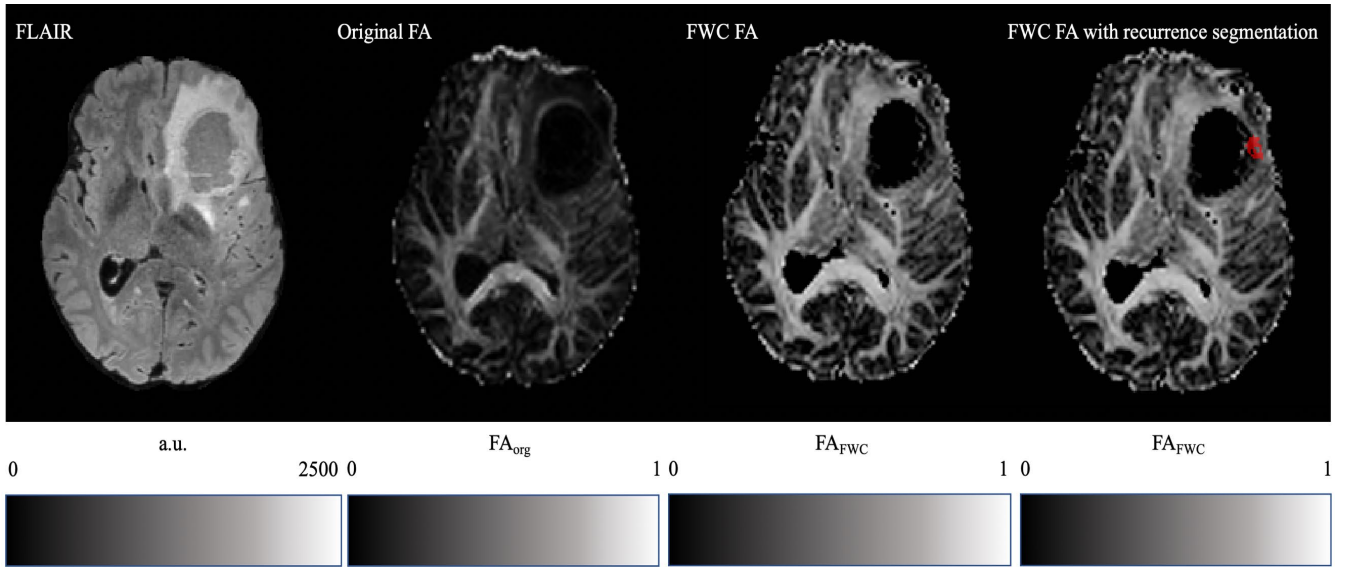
Comparison of original and FWC FA maps in gray scale. For reference, again the preoperative FLAIR image is added on the left. FWC of FA maps reveals more information about the tissue microstructure in the area of peritumoral edema. As a special region of interest, the recurrence site is marked in red in the image on the rightmost.
